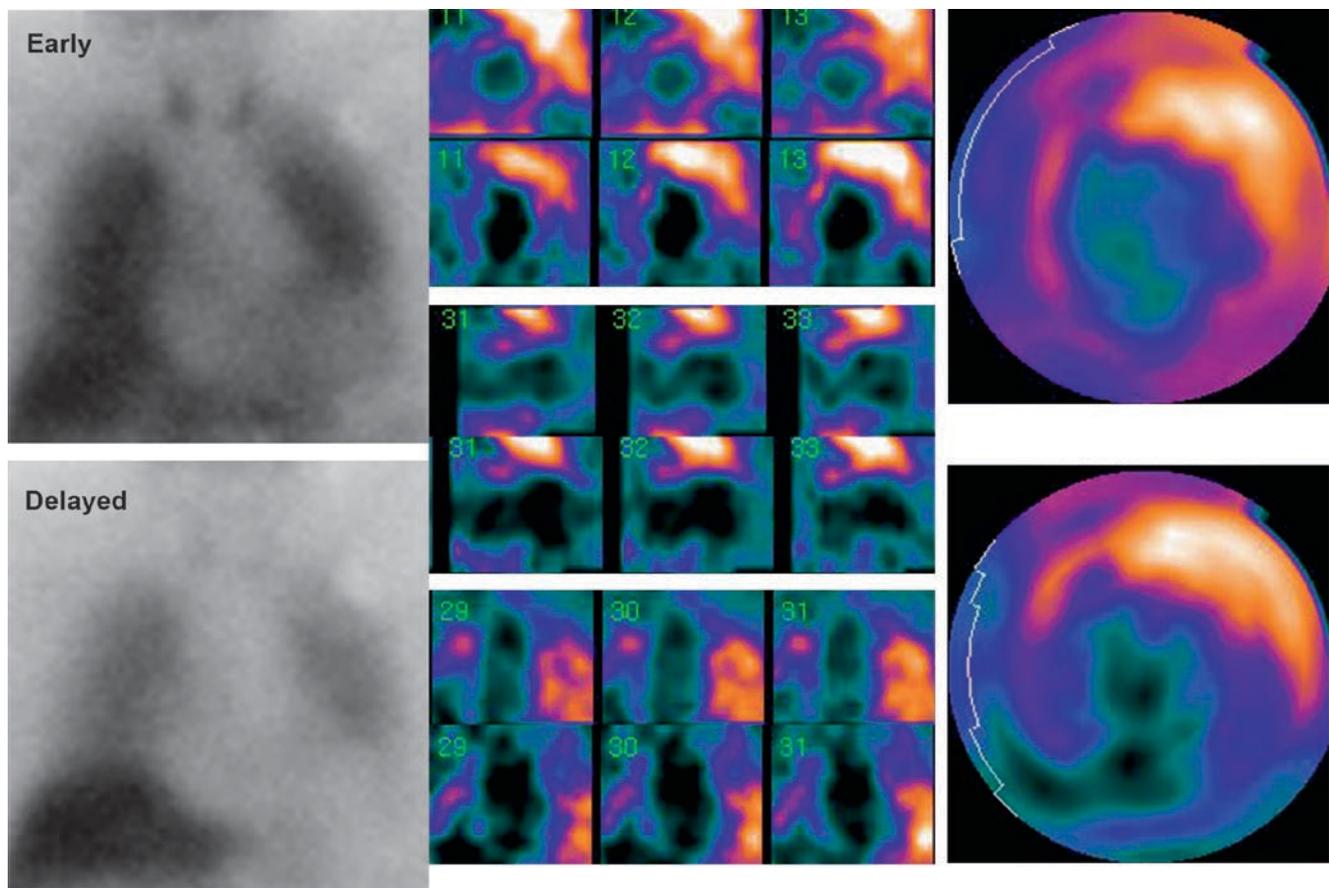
^{123}I -MIBG planar and SPECT studies of a patient with ischaemic dilated heart disease and LVEF of 20%. Heart-to-mediastinum ratios: early 1.25, late 1.15; wash-out rate 30%. SPECT images correspond to early and late standardized axes slices with respective polar maps
